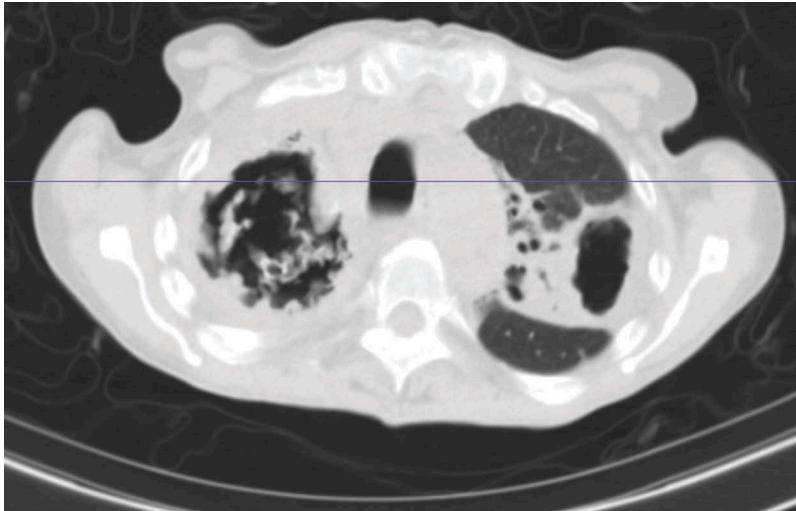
(a) Cross section chest CT scan, (b) Coronal section chest CT scan.
